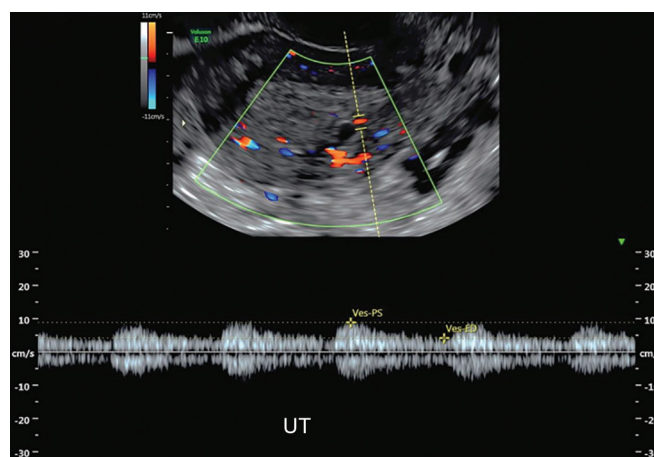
Pulsed Doppler waveform analysis reveals moderate vascular impedance signals (RI 0.53) obtained from the periphery of the myometrial cyst
